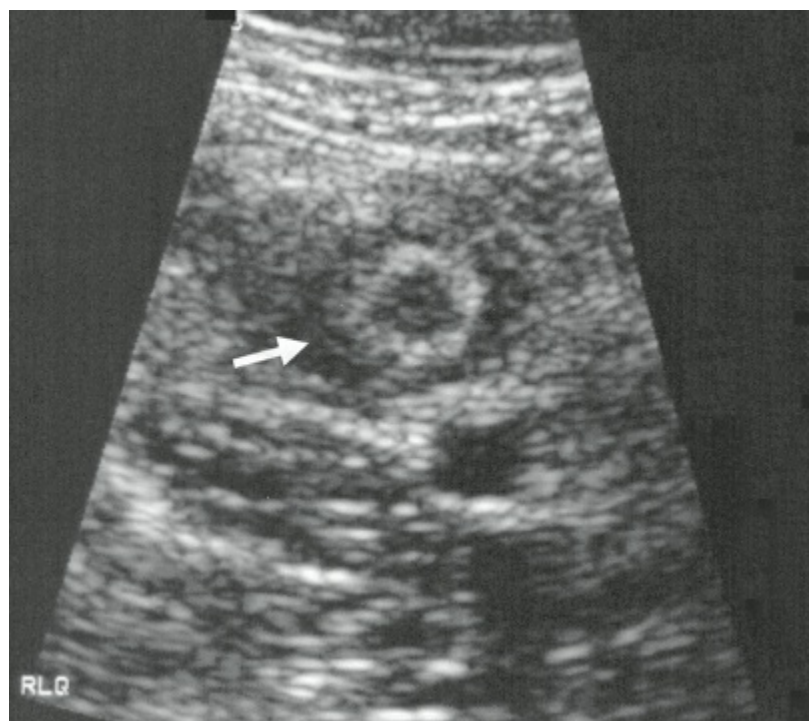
Ultrasonographic appearance of appendicitis. The appendix appears as a thick, noncompressible tubular structure with central hypoechogenicity. The walls are 5-mm thick, over the 3-mm limit for a normal appendix. (Courtesy of Dr. Beverly Coleman, Department of Radiology, Hospital of the University of Pennsylvania, Philadelphia, PA.)
